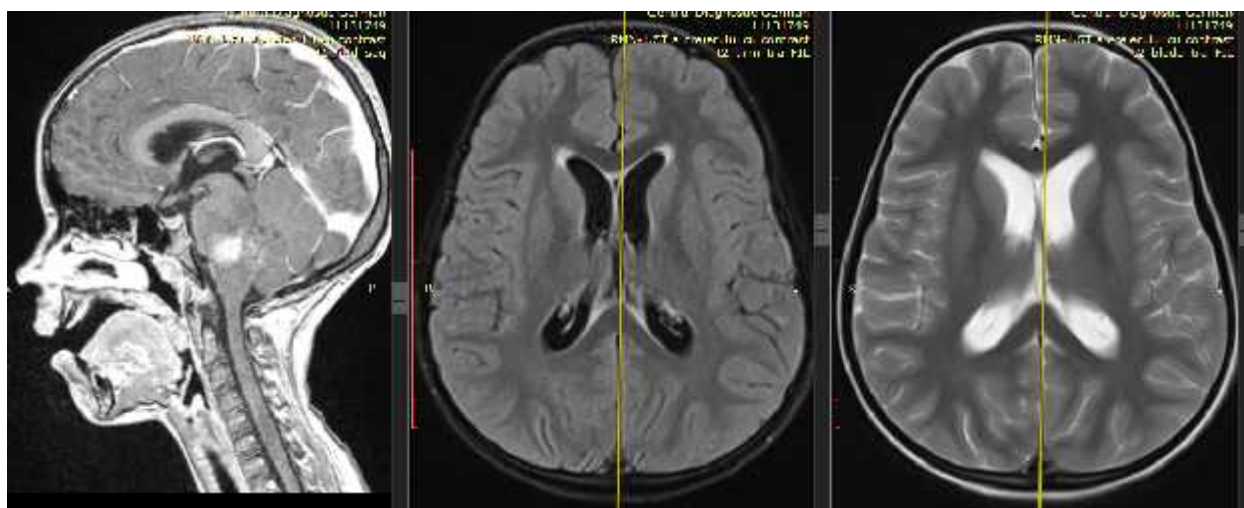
Patient L., 9 years. Preoperative MRI: periventricular edema and the obstruction of the adjacent to the tumor liquorian pathways
